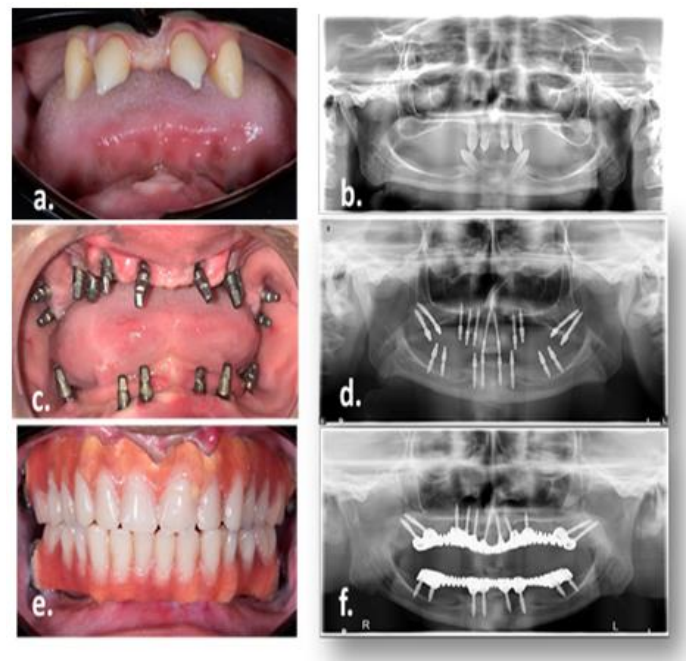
Intraoral and Radiographic presentation of the treatment. a. Preoperative picture showing retained teeth. b. Preoperative OPG. c. Implants placement. d. Positions of implants. e. Prosthesis placed on the implants. f. Postoperative OPG.
